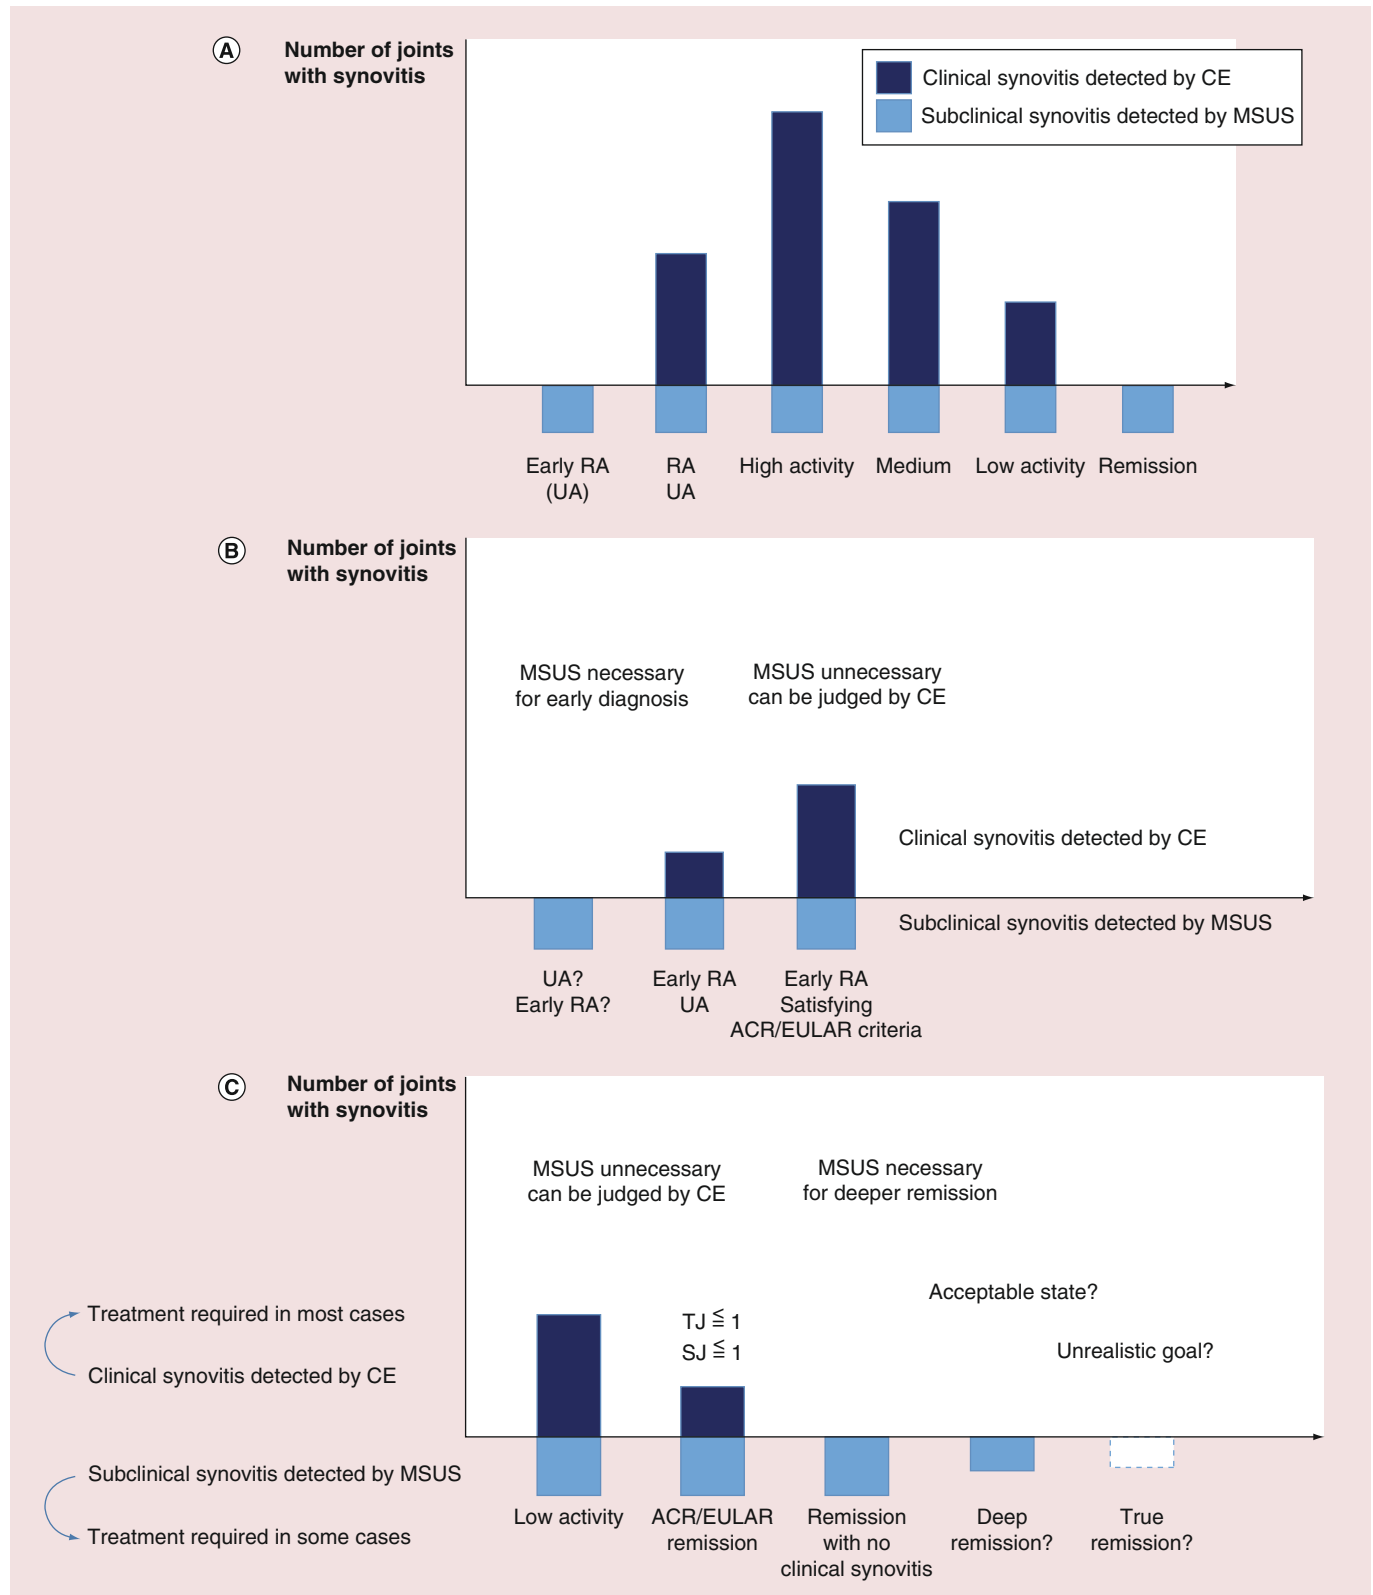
Numbers of joints with synovitis at different stages. (A) Progression of RA. (B) Onset of RA. (C) Remission of RA. CE: Clinical examination; MSUS: Musculoskeletal ultrasonography; UA: Undifferentiated arthritis.
